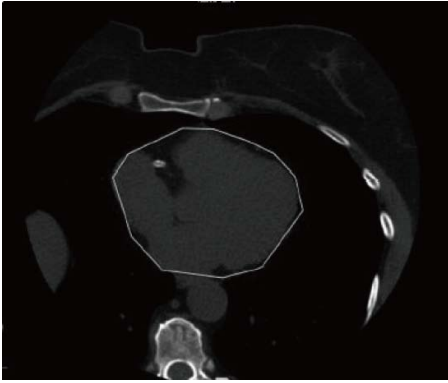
Measurement of epicardial fat volume; the electronic line delineates the contour of epicardium in noncontrast computed tomography.
